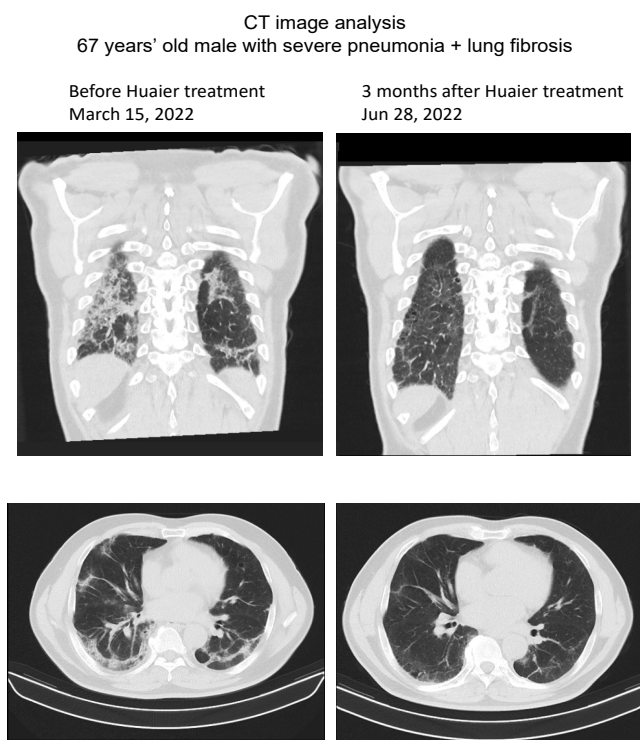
Chest CT image analysis before (March 15) and after 3 months of Huaier treatment on the patient (June 28).
